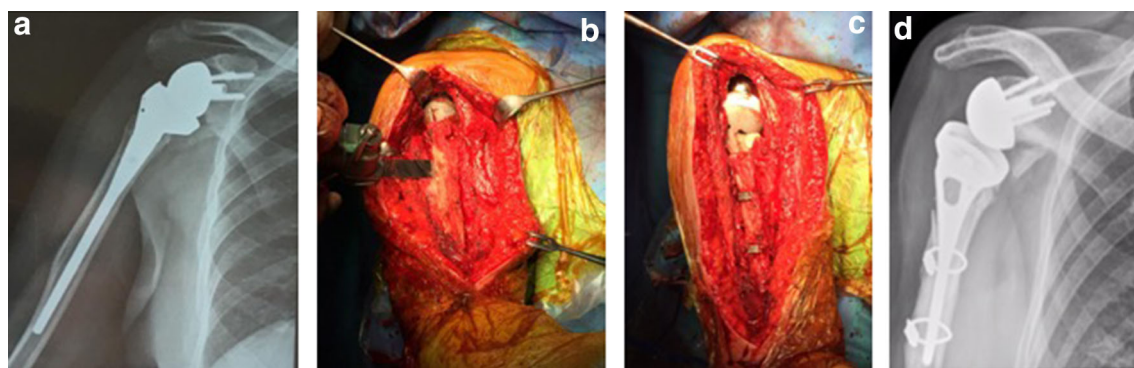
Painful RSA in a patient with a documented nickel and palladium allergy. a Absence of radiographic signs of loosening in patient with a painful RSA in proximal humeral fracture sequelae. b Opening of the humeral diaphysis for removal of prosthetic component.
